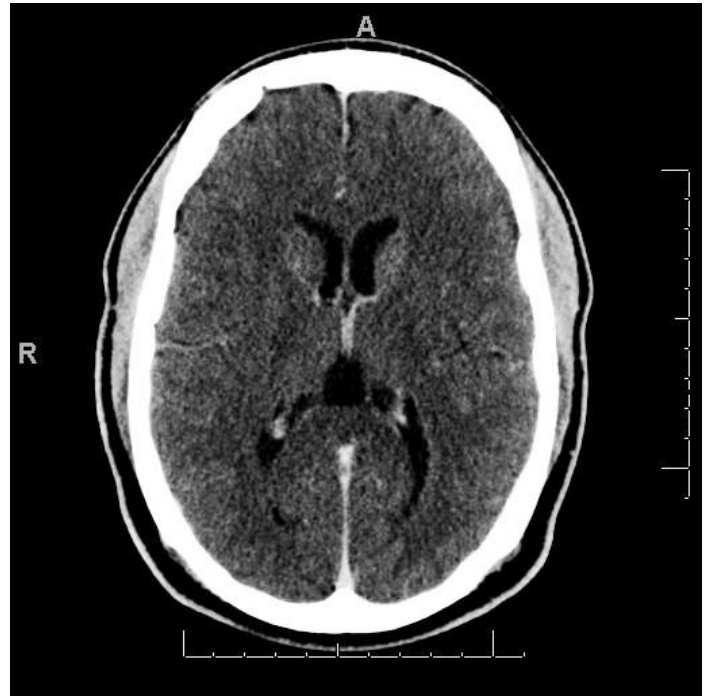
Brain CT-Scan with contrast showing mass-like heterogeneous enhancement in the right caudate nucleus.
